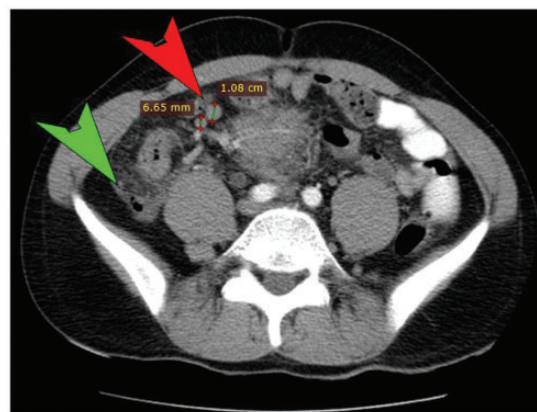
Computed tomography. Several round lymph nodes are seen in the radix mesenterii (red arrowhead). The retroperitoneal fat is hyperdense and edematous (green arrowhead), indicating inflammatory dissemination.
